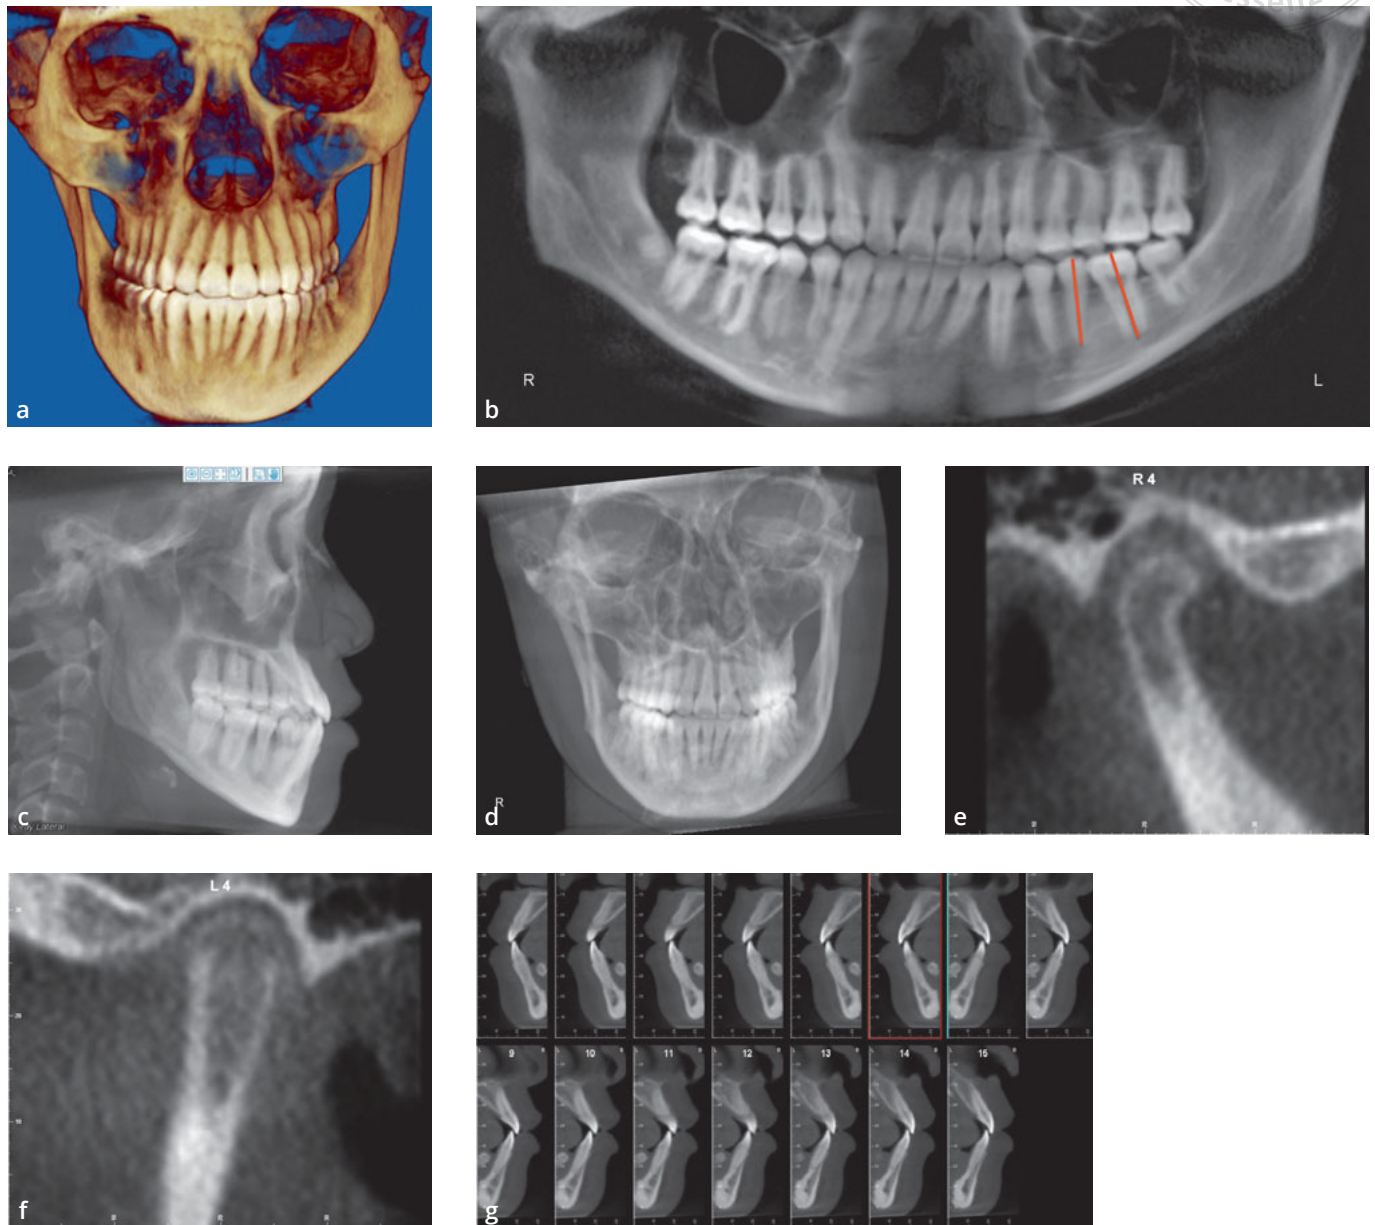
to g Final cone beam computed tomography (CBCT) imaging. (a) CBCT driven frontal image. (b) CBCT driven panoramic radiograph showing parallelism of the roots of the mandibular left second premolar and mandibular second molar, (c) CBCT driven lateral cephalometric projection, (d) CBCT driven frontal cephalometric projection, (e and f) Right and left CBCT driven temporomandibular joint imaging after treatment showing more uprighting of the right condyle than before treatment, (g) CBCT driven labiolingual-sagittal screen of the anterior teeth showing uprighting of mandibular incisors and correction of the anterior crossbite.
